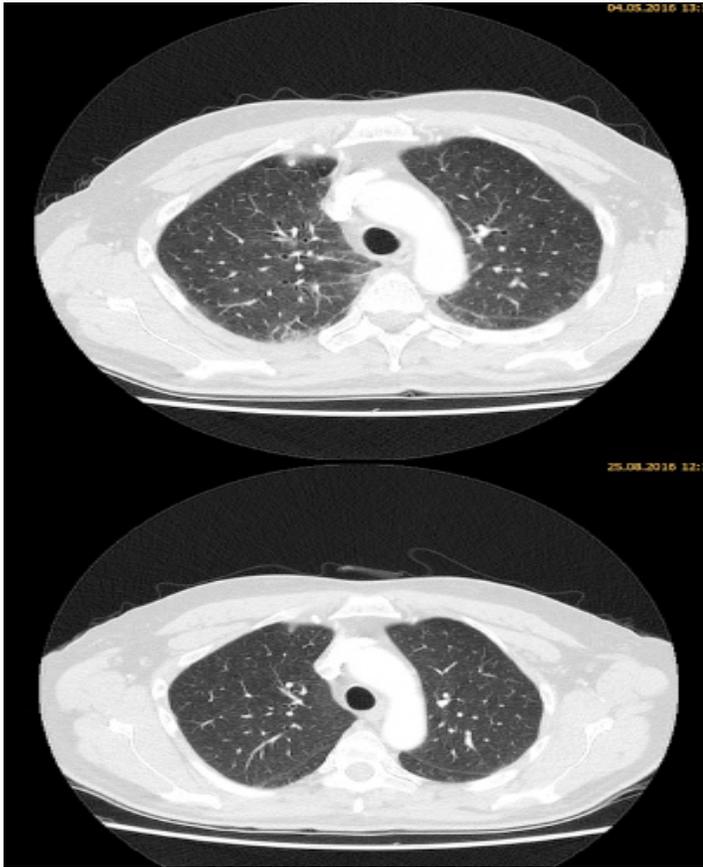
Chest CT showing interstitial infiltrates and bilateral basal ground-glass opacities (upper image) and their resolution after a 3-month period (lower image).
